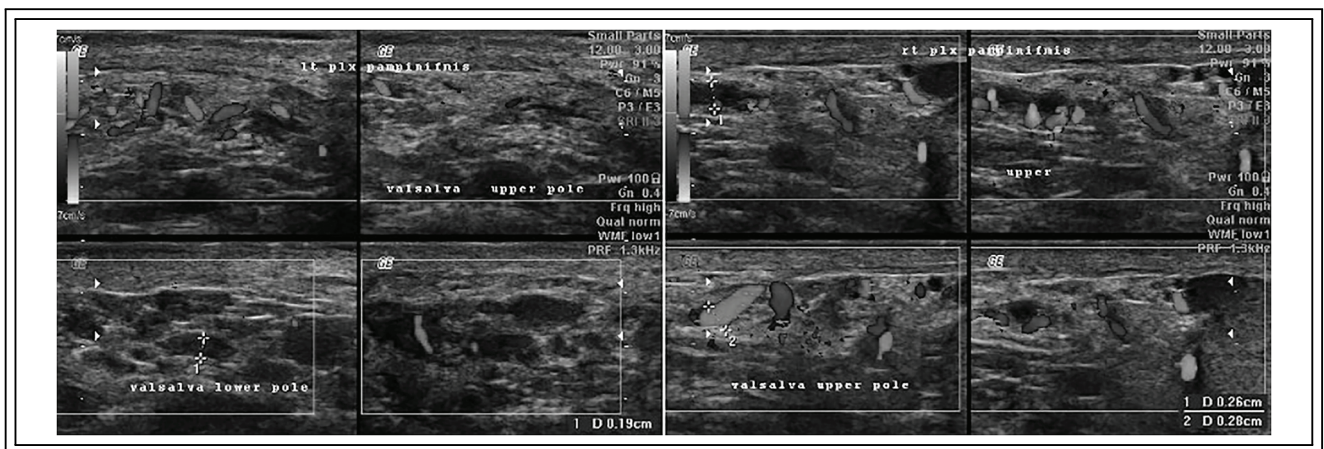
Doppler ultrasonography of the left and right pampiniform plexus
